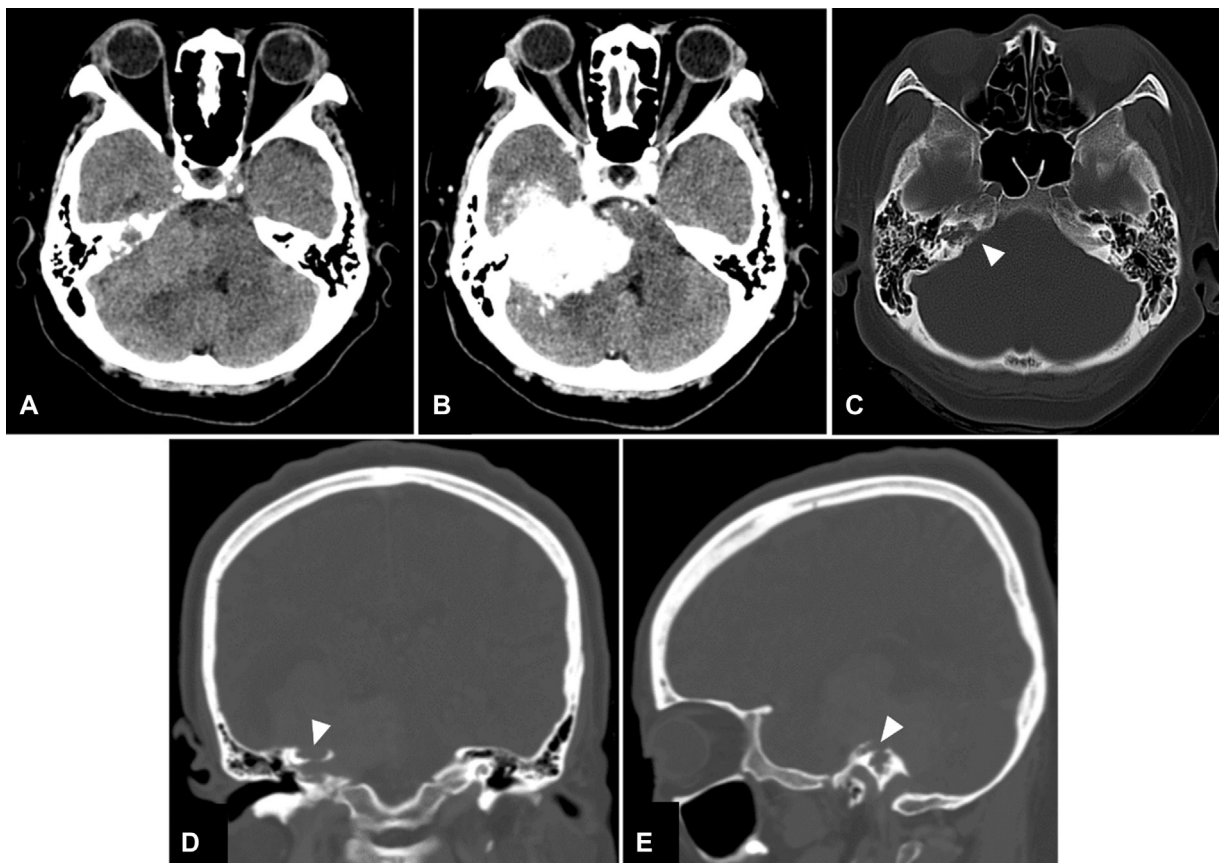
Axial computed tomography (CT) scan of the brain (A) without and (B) with contrast reveal a large homogeneously enhancing extra-axial mass involving middle and posterior cranial fossae with marked brainstem compression. (C) Axial, (D) coronal, and (E) views of bone-window CT scan demonstrate destructive changes (arrowheads) of the right internal auditory canal and labyrinthine structures.
